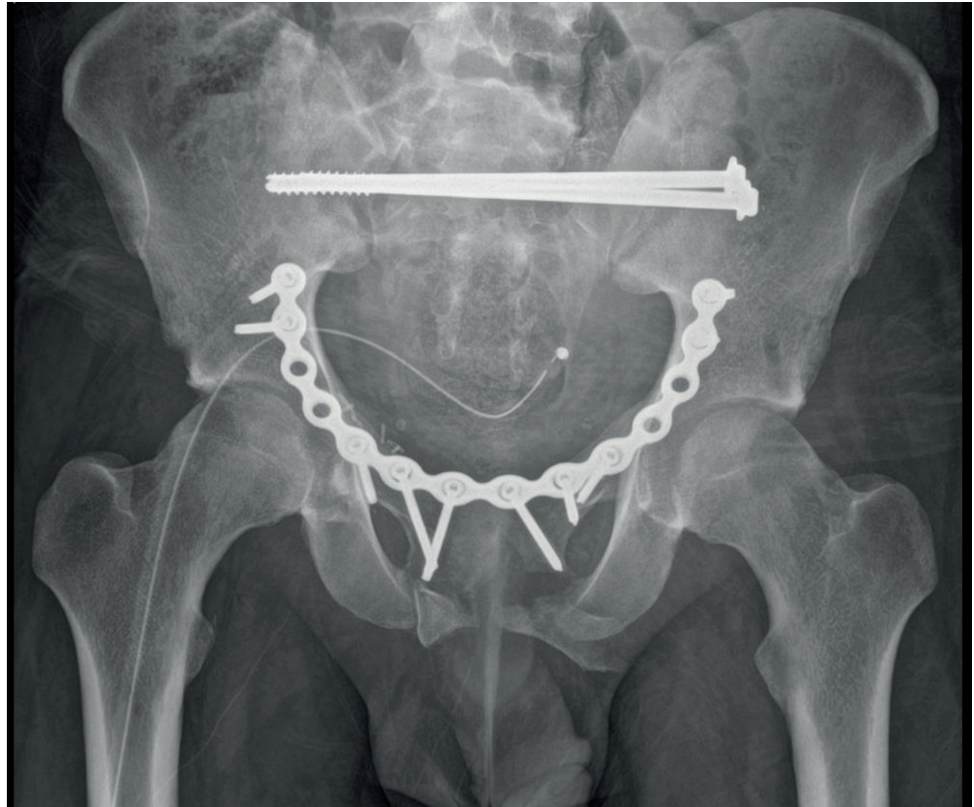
Anterior-posterior X-ray of the pelvis post fixation with a 14-hole plate and sacro-iliac screws.
